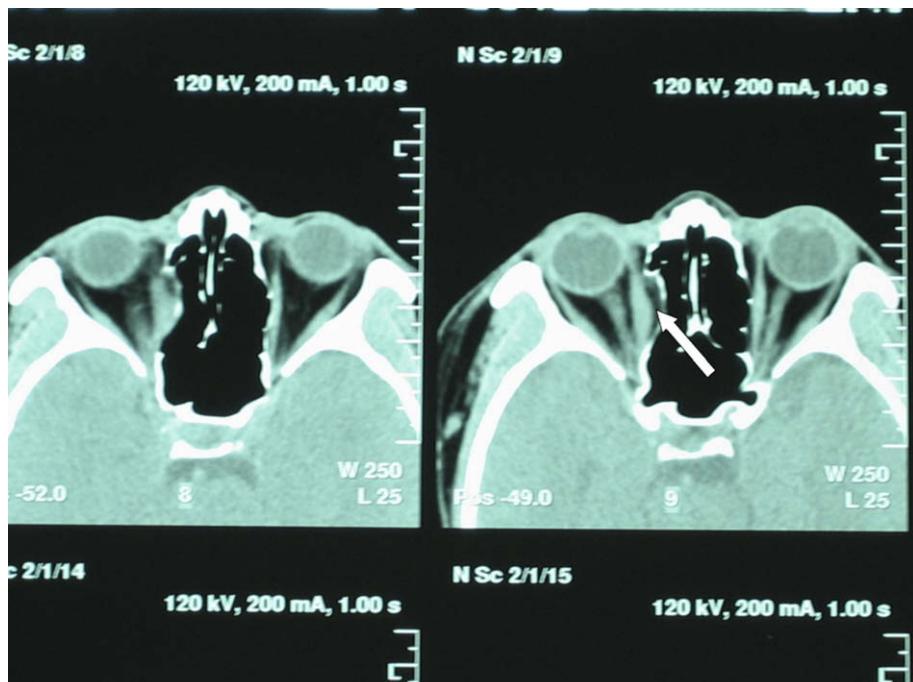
CT direct sign: left eye, orbital medial wall displaced and curvature changed; indirect sign: medial rectus muscle of eyeball thickened (see white arrow).
